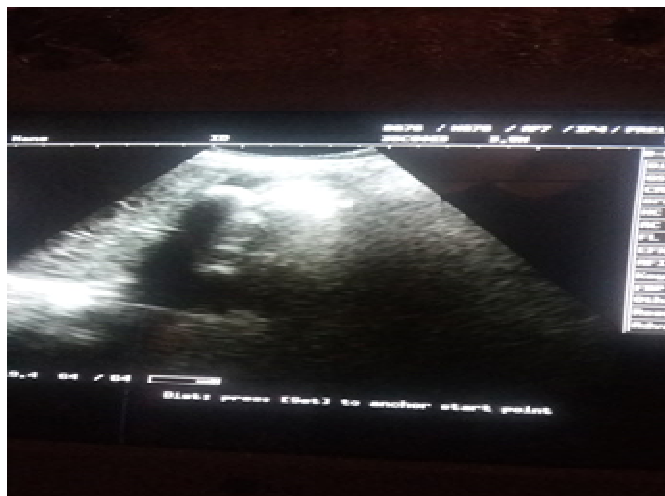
Ultrasound image of 25years female showing multiple gallbladder stone.
